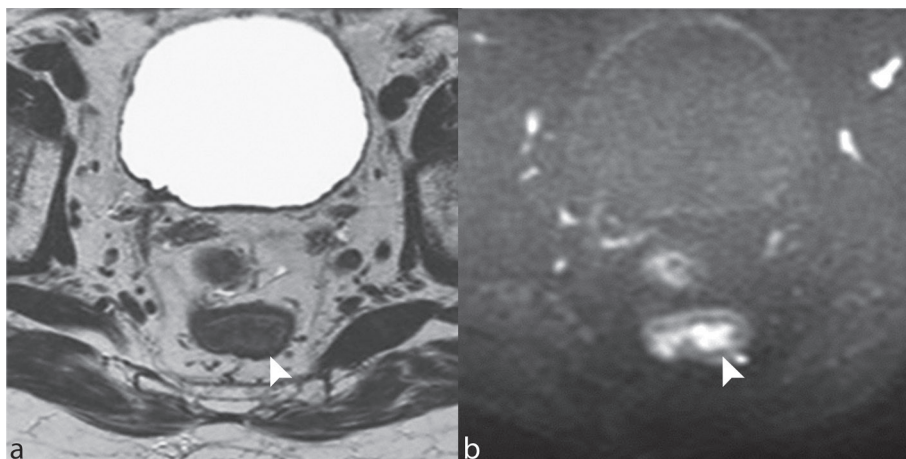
T2-weighted MRI (a) and b1000 s/mm² DWI images (b) of a male patient with a small tumour (white arrowhead) that is hard to detect and initially missed on T2-weighted MRI, but is clearly visible on DWI.
